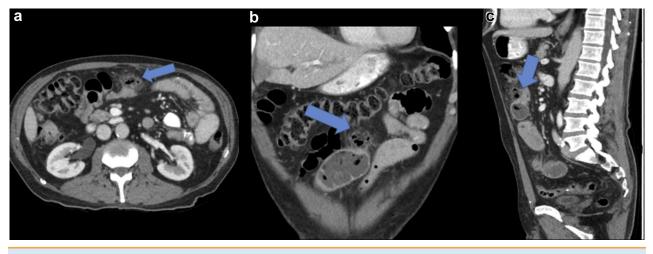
(a, b) Axial and coronal contrast-enhanced abdominal CT images from a 56-year-old man presenting with a 6-day history of increasing abdominal girth, no bowel motion or flatus. The images show an obstructing apple core mass in the sigmoid colon with an associated large bowel obstruction and free fluid. The gas pattern of the caecum is suspicious for ischemia. The blue arrow shows an obstructing apple core mass in the sigmoid colon with an associated large bowel obstruction and free fluid.
